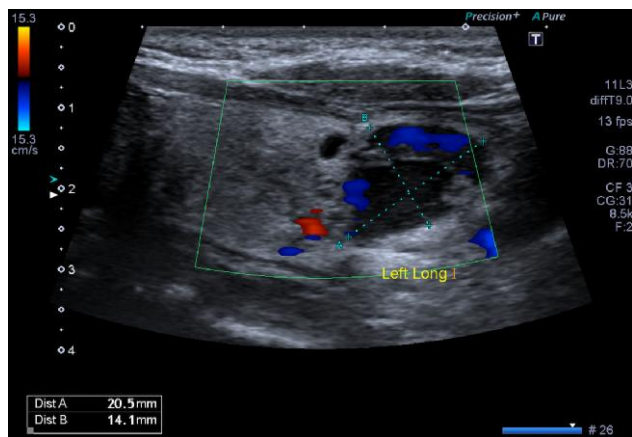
Ultrasound of the neck suggestive of a mixed cystic solid nodule of the inferior left thyroid lobe.
